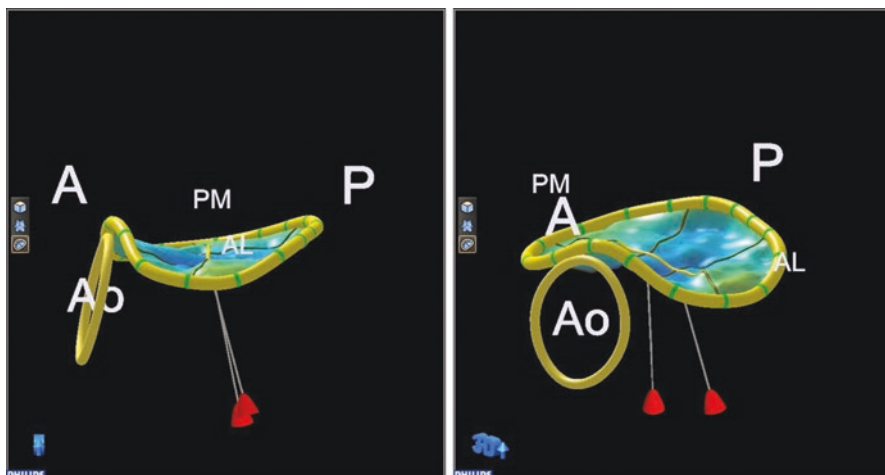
Three-dimensional echocardiography mitral valve model demonstrating the normal saddle shape of the mitral valve annulus, meant to ensure a smaller projected mitral valve area for the mitral valve leaflets to cover in systole and less leaflet stress. The annulus bends in systole, accentuating the saddle shape and further reducing the projected mitral valve area
